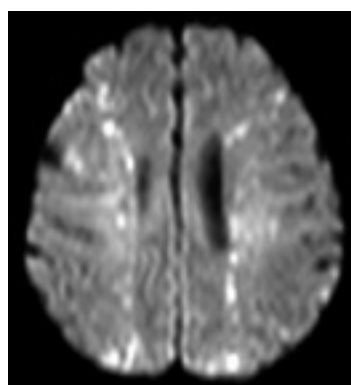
Diffusion-weighted MR images obtained 48 h after TACE shows multiple hyperattenuating and hypertensive punctate-patchy lesions in both cerebral hemispheres.
